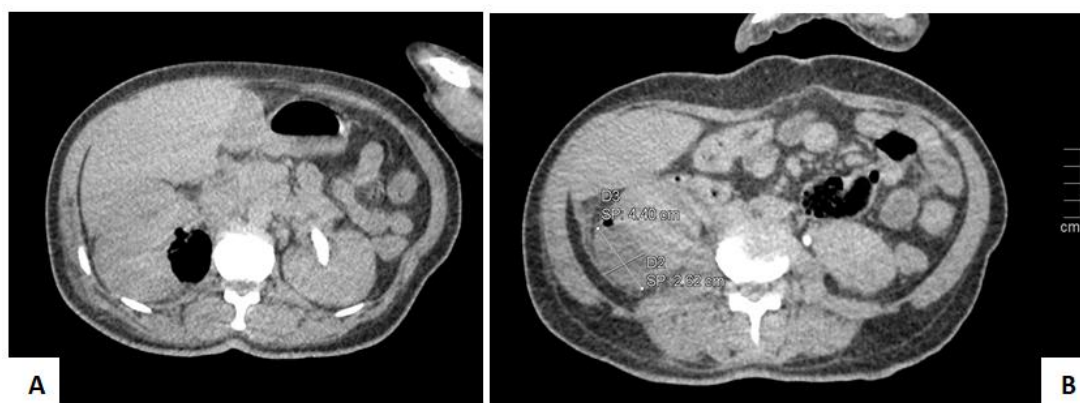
CT scan showing air bubble at the level of renal parenchyma (A) and abscess in the inferior pole (B)
